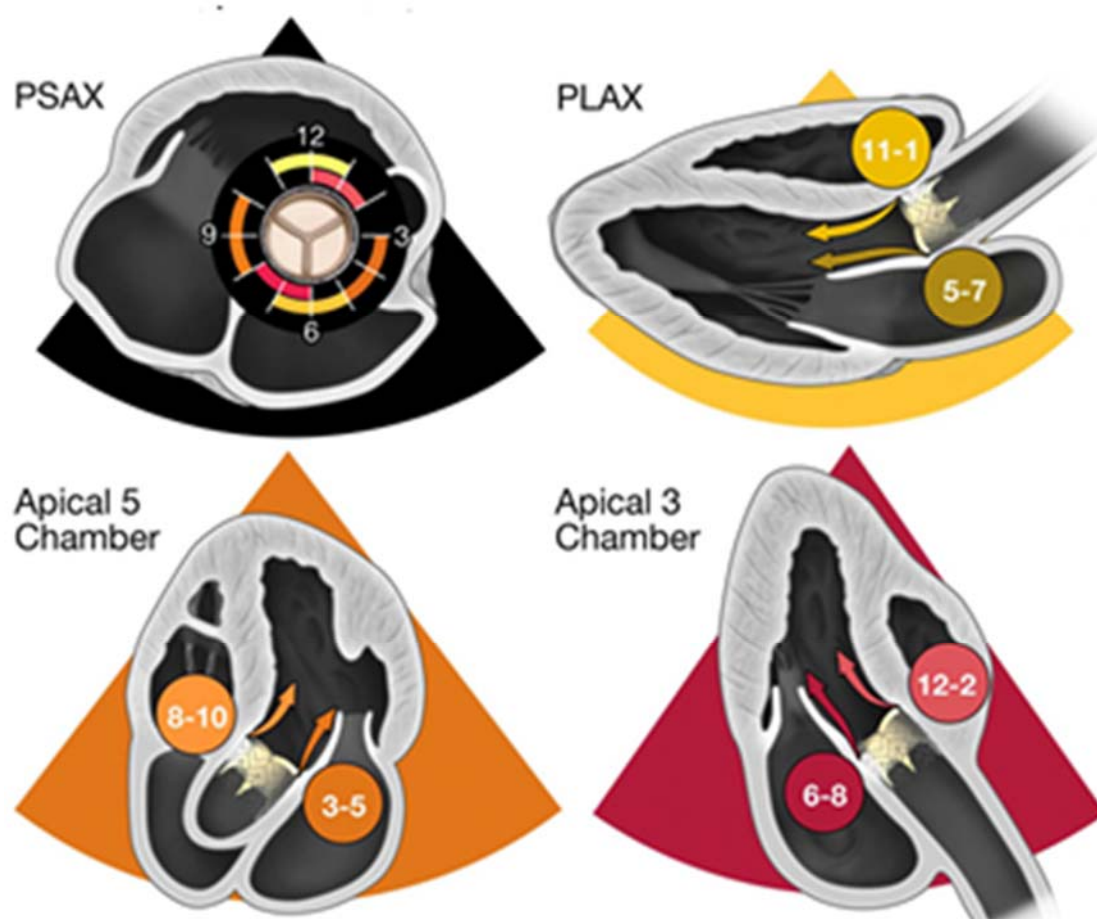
Standard views showing detection of paravalvular regurgitation. Color coding delineates the regions around the valve that can be visualized from the parasternal and apical views. With ultrasound plane rotation, tilting upwards or sideways, a more complete interrogation of the valve can be accomplished. Apical views are important in that some jets may not be detected in the parasternal views because of shadowing from the prosthesis. [Journal of the American Society of Echocardiography 2019 32:431-475 DOI: (10.1016/j.echo.2019.01.003, Copyright © 2019 American Society of Echocardiography]
